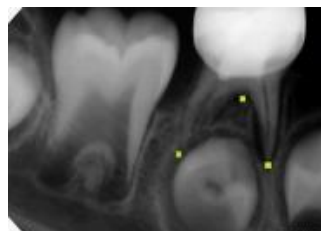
27: Densitometric analysis of periapical mesial, distal and furcation areas using Digora system software
